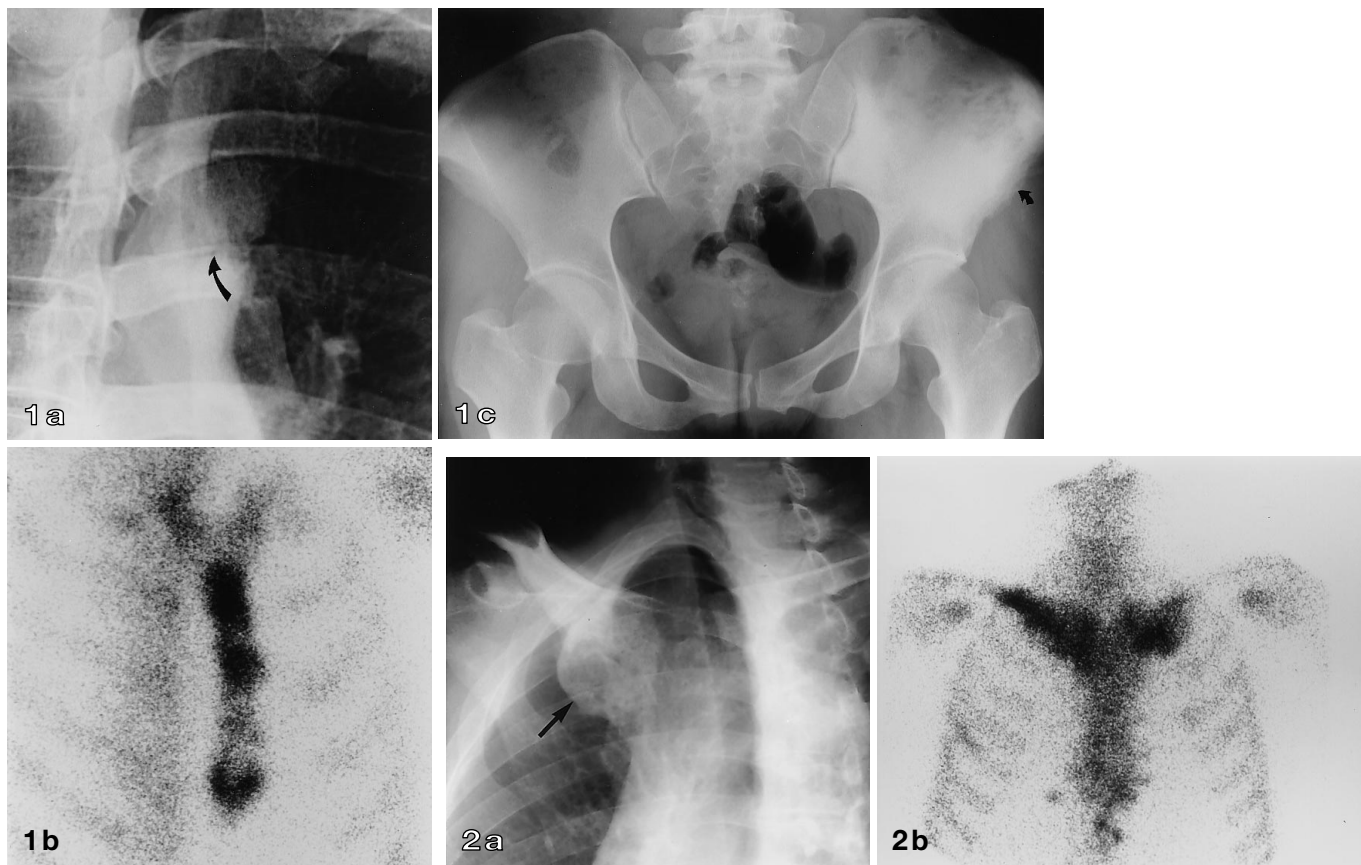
A 31-year-old woman with PPP. a Left posteroanterior oblique view of the sternum shows irregularities and sclerosis of the manubriosternal joint (*arrow*). b Left anterior oblique projection of this bone scintigraph shows increased tracer uptake in the sternum. However, no increased activity is seen in the manubrium, costosternal joints, and clavicle. While there appears to be an erosion in the manubriosternal joint on plain radiography, the lesion is limited to the sternal body. c Anteroposterior radiography of the pelvis shows diffuse sclerosis of the left iliac bone. Fluffy periosteal new bone formation is seen along the iliac wing (*arrow*). The sacroiliac joints appear normal
